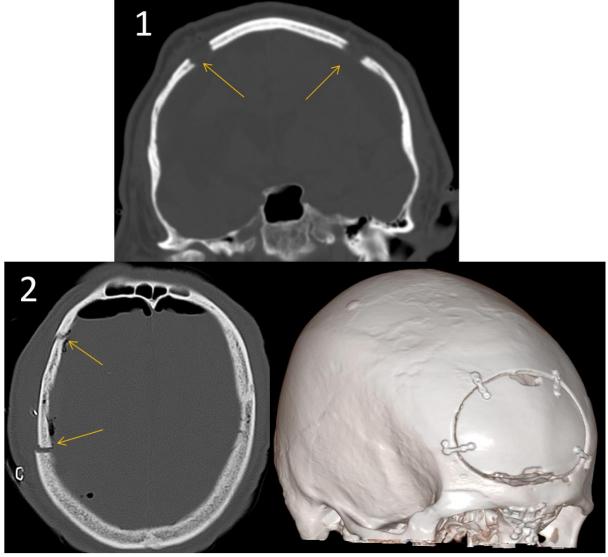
CT images of neurosurgical intervention following TBI; 1: Bilateral burr hole (arrows) to evacuate hemorrhage or insertion of ICP monitors, 2: Craniotomy involving removal of bone flap for evacuation of hemorrhage with reinserted bone flap (arrows). Courtesy of Neuroradiology department (OUS-Ullevål), with permission.
